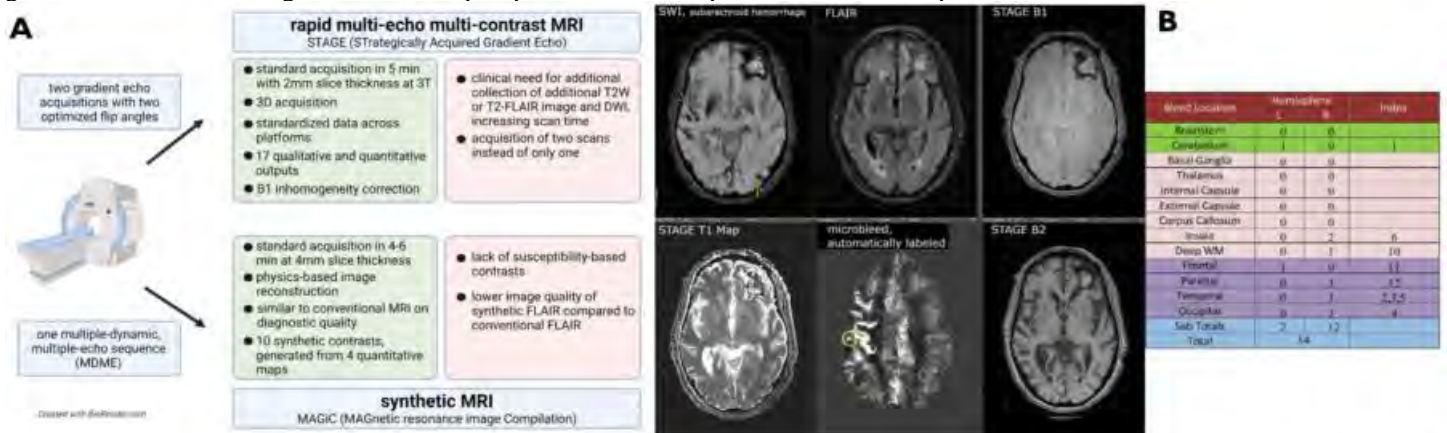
A) Comparison of rapid multi-echo multi-contrast- and synthetic MRI acquisitions; B) representation of images obtained on a patient with acute stroke and multiple microbleeds using STAGE-MRI, output format for automated reporting of microbleeds.
